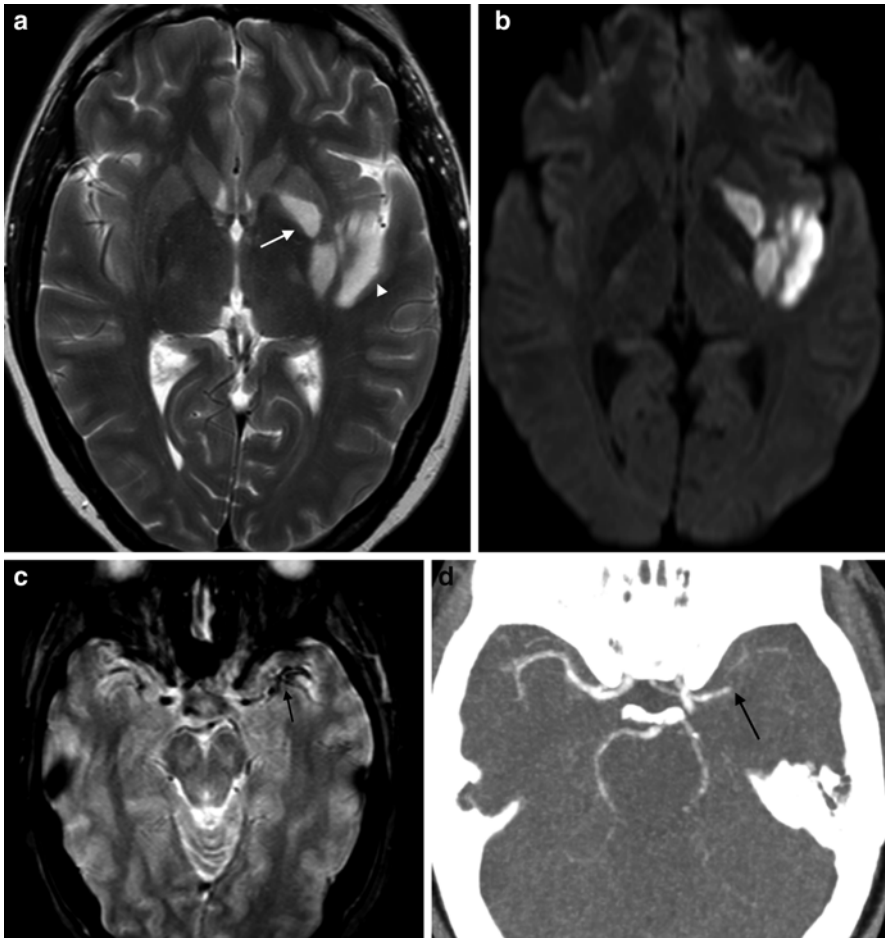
MCA thrombosis. (a) Axial T2 image in a patient with acute right hemiparesis shows signal abnormality in the left putamen (*arrow*) and left insula cortex (*arrowhead*). (b) DWI shows hyperintensity in congruent regions, indicating acute infarction. (c) Axial T2* imaging shows hypointensity of the left M1 and M2 branches. Magnetic susceptibility due to deoxyhemoglobin in thrombus results in “blooming” and signal dropout. (d) CT angiogram confirms occlusion of the left M1
